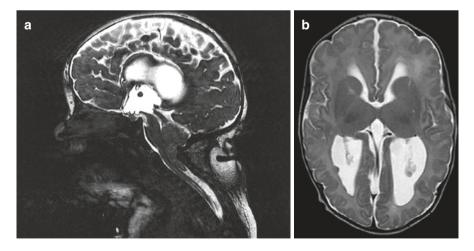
MRI in a patient with severe hindbrain malformation related to MM with a severely condensed posterior fossa, and tonsillar and cerebellar herniation (a). Colpocephaly—select enlargement of the occipital horns—is demonstrated (b)
